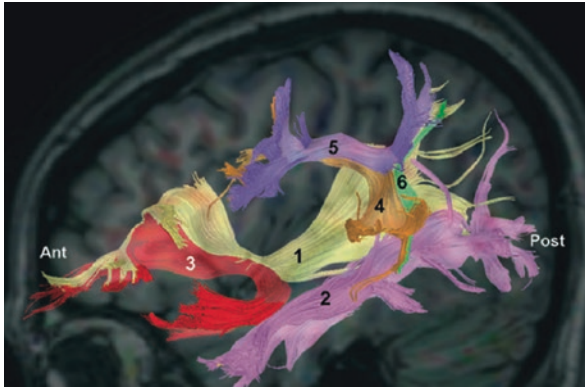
DTI tractography reconstructions of white matter pathways of the language network. The figure shows a 3D sagittal view of (1) Inferior Fronto-Occipital Fasciculus (yellow), (2) Inferior Longitudinal Fasciculus (pink), (3) Uncinate Fasciculus (red), (4) Arcuate Fasciculus (orange), (5) horizontal segment of the Superior Longitudinal Fasciculus (purple), (6) vertical segment of the Superior Longitudinal Fasciculus (green). The tracts are overlaid on a sagittal T1-weighted image for anatomical reference. (Source: [100])
